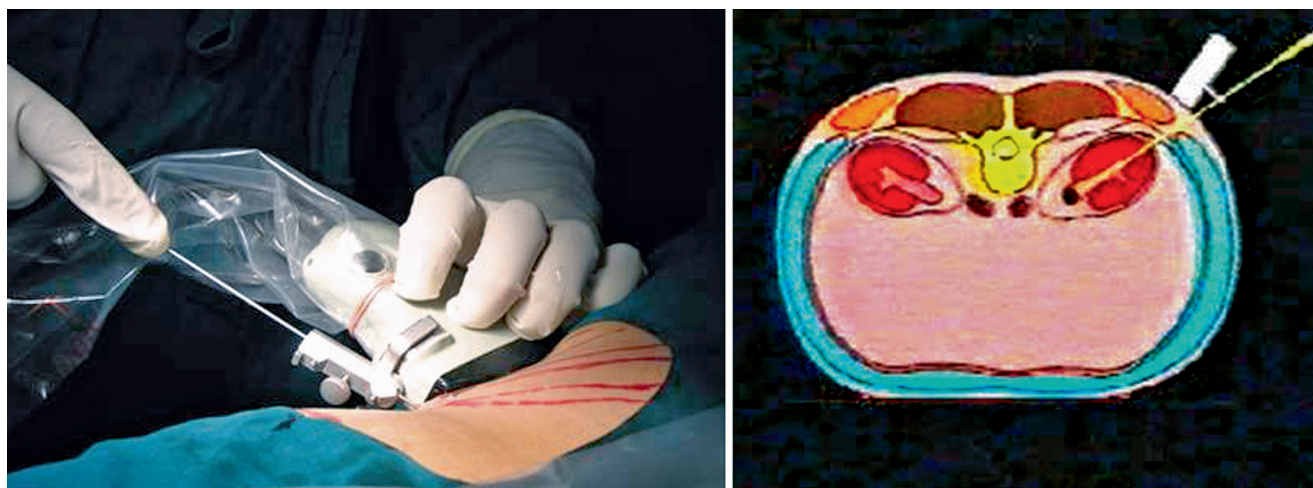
The needle housed in the needle attachment helps in accurate access. (a) The needle housed in the needle attachment helps in accurate access. (b) The ultrasound guided access helps in gaining a straight tract from the skin to the calyx
